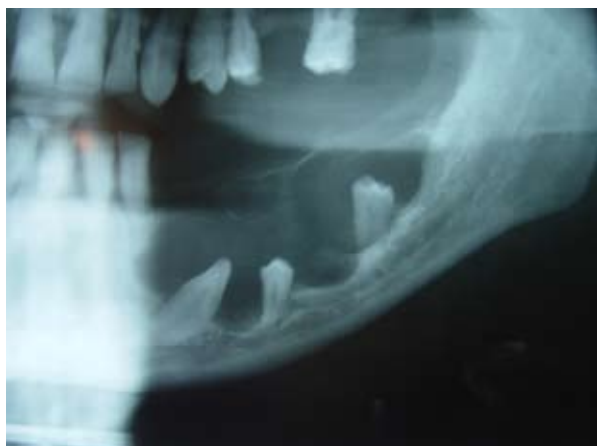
Panoramic radiograph showing radiolucency in the left posterior mandible.
